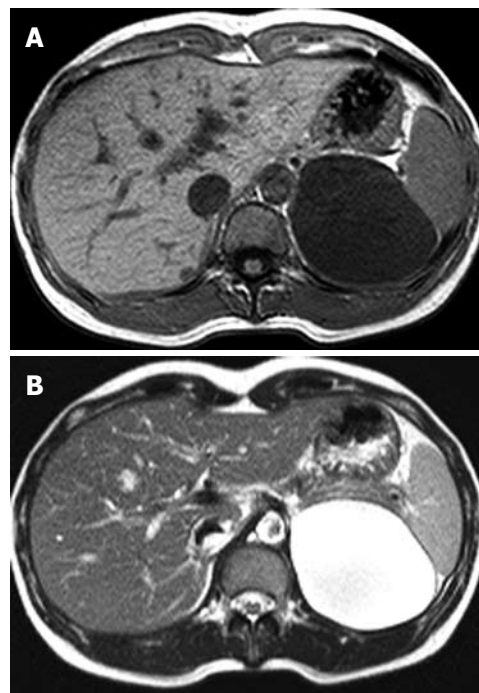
Magnetic resonance imaging of the abdomen. A low signal intensity cystic mass on the T1-weighted image (A) and a high signal intensity cystic mass on the T2-weighted image (B).
